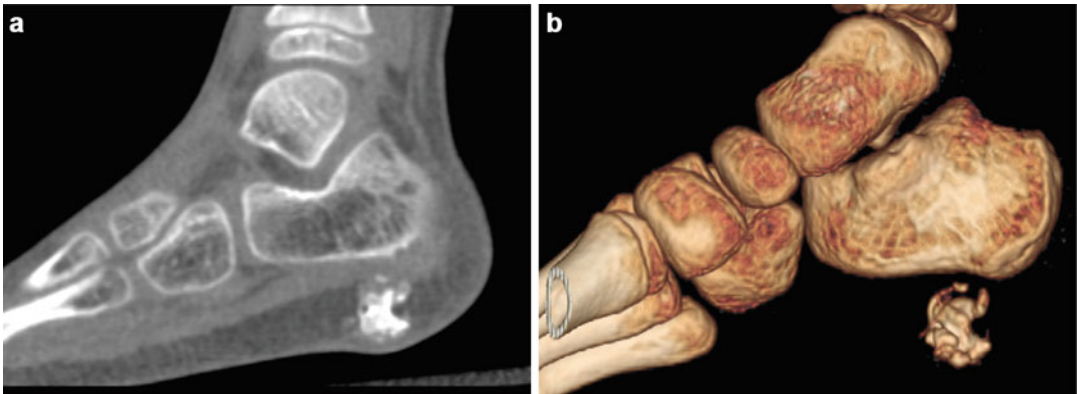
(a, b) The patient was a healthy 3-year-old female with a history of a small mass on her right heel pad for over a year. Recently, she had intermittently complained of pain associated with slightly increased mass size. Plain CT (a) and 3D reconstruction CT (b) images of the right foot demonstrated an irregular calcification centered in the subcutaneous fat plantar and slightly medial to the posterior body of the calcaneus. There was an accompanying soft
